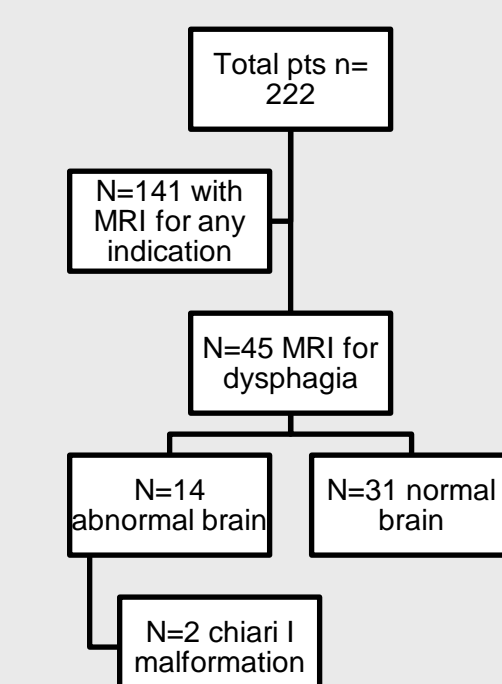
Brain MRI without syndromic status
